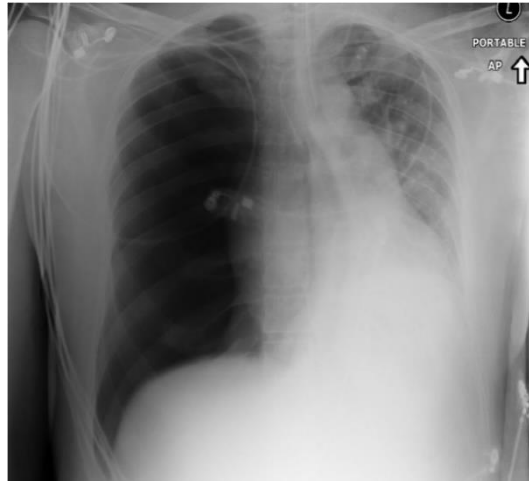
X-ray imaging of pneumothorax
